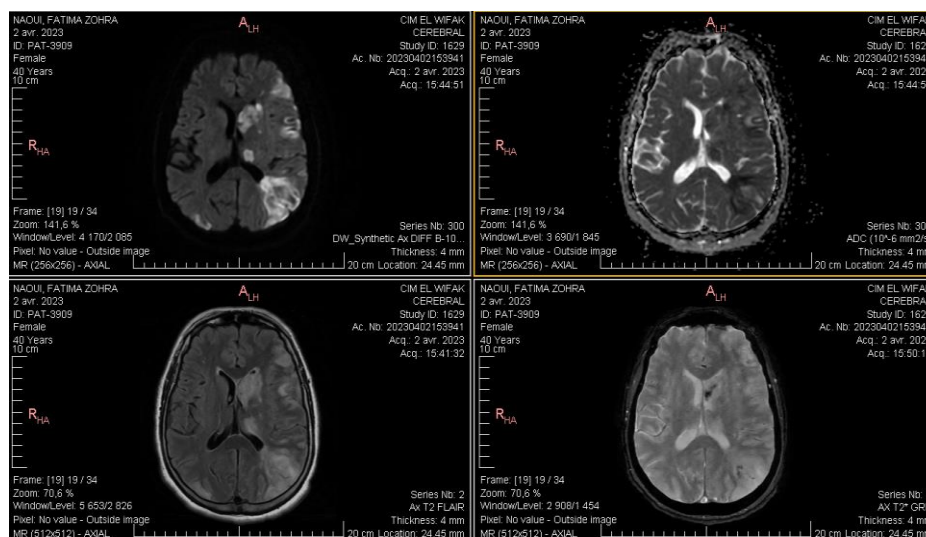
Multiple hyperintense signals on T2 FLAIR sequence with restricted diffusion and decreased ADC values, not systematically distributed, with some areas showing hemorrhagic transformation.
